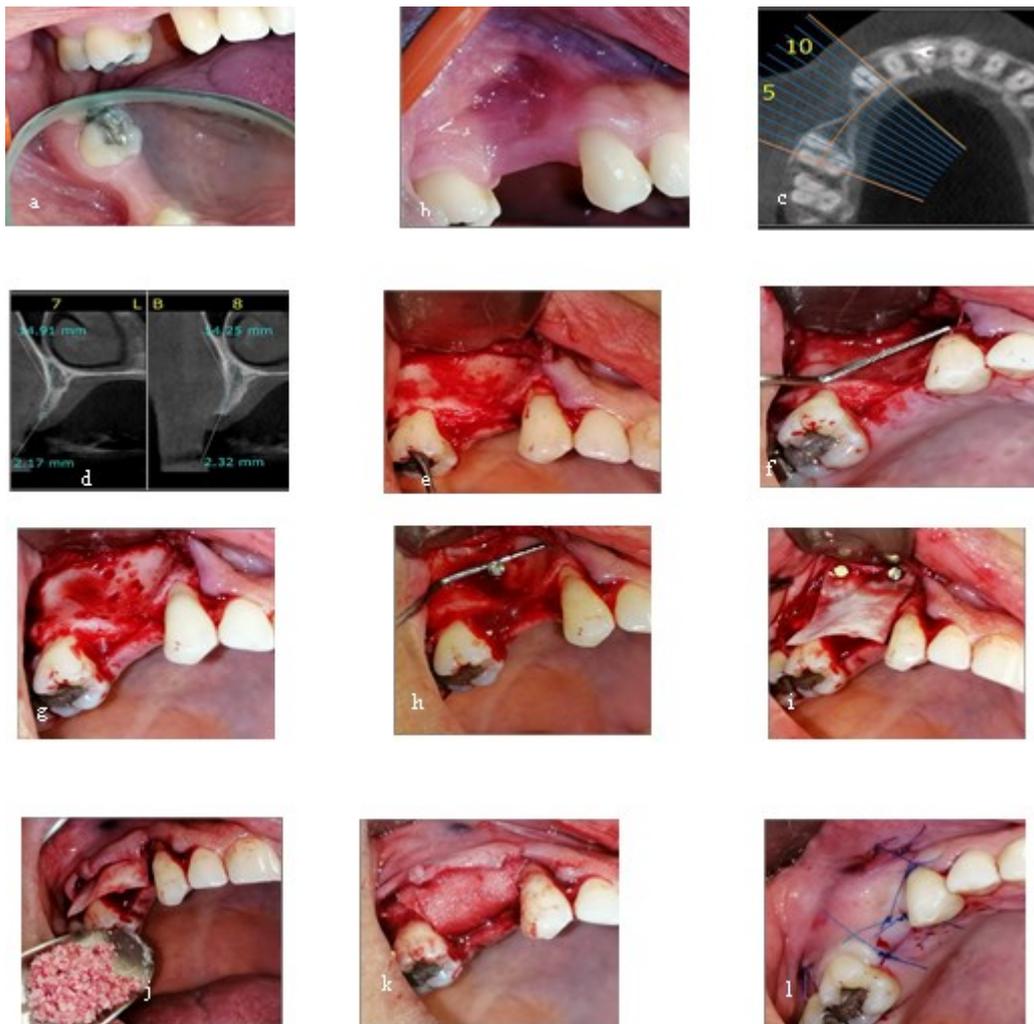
Clinical and radiographic views of the treatment procedure in the first surgery
